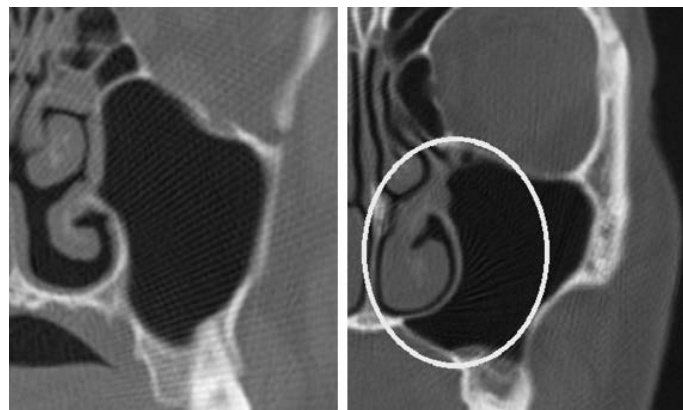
CT Axial Slice and Coronal Reconstructions. Types of Maxillary Sinus Recesses (Pockets). Alveolar and palatine Recesses. The lower wall of the maxillary sinus is formed by the alveolar process of the maxilla (processus alveolaris maxillae).
